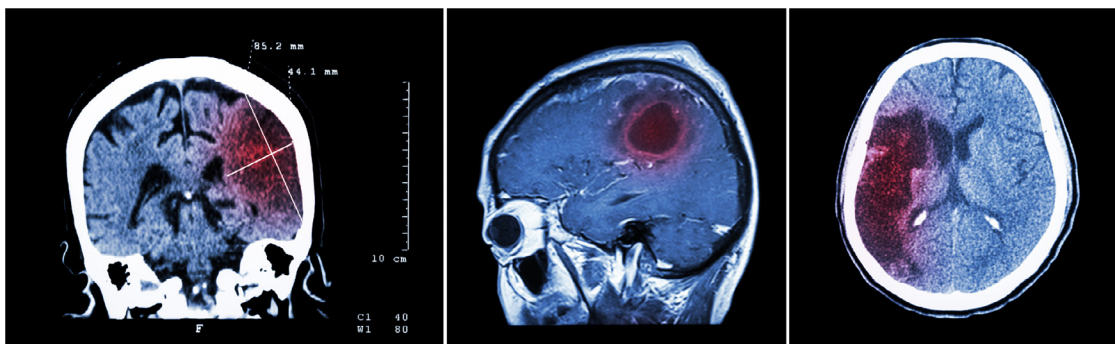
An MRI for an Ischemic Stroke Case.
